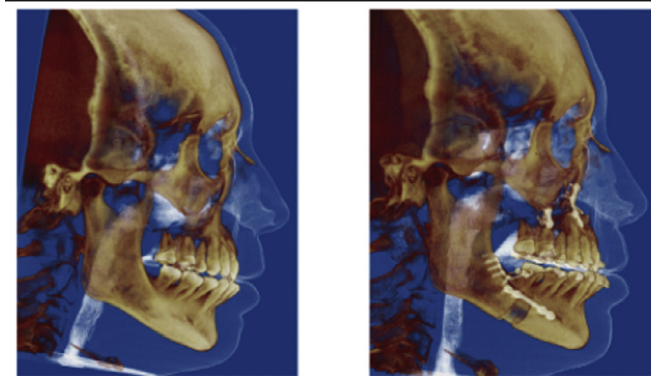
Initial and post-surgical CBCT Images morphing hard and soft tissues.
